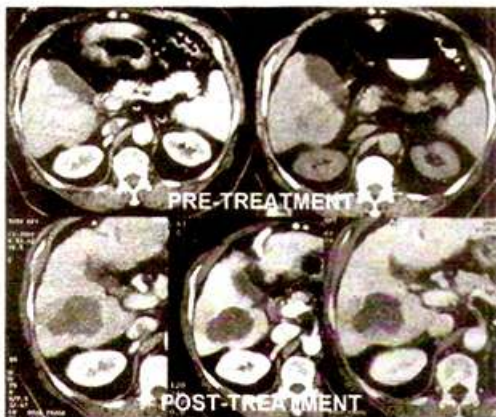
Pre-treatment computed tomogram of liver showing vascular mass (arrows) in segment VI, and complete necrosis and reduction in size (arrows) one year after radiofrequency ablation
